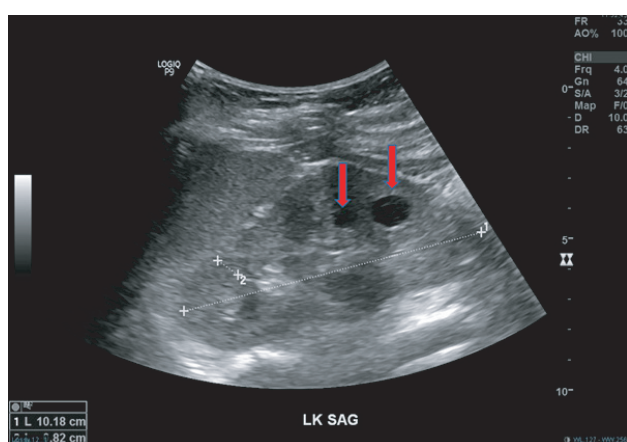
Ultrasound image of the left kidney. It showed bipolar length of 10.18cm with cortical thickness of 1.4cm. There were two renal cysts (red arrows) seen at the lower pole of the kidney.
